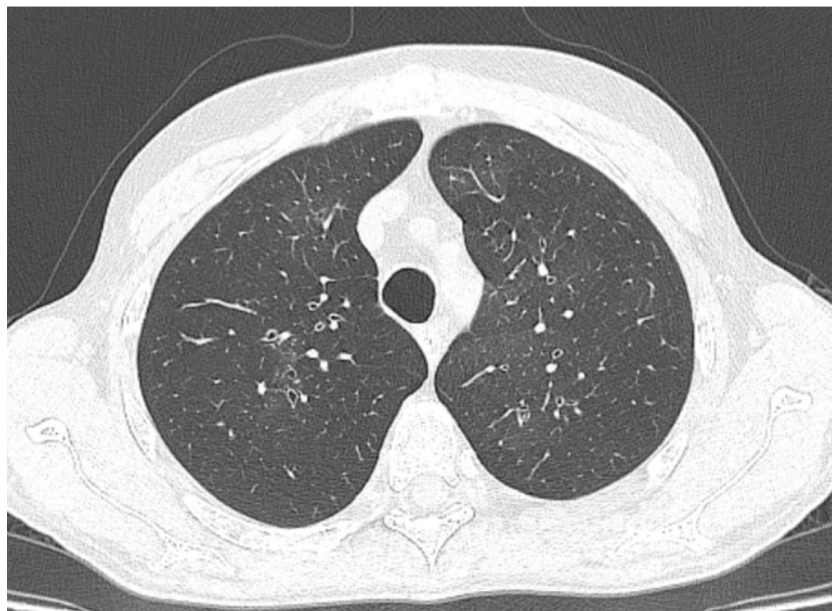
HRCT - Bilateral diffused mosaic attenuation patterns representing air trapping and bronchiectasis.
